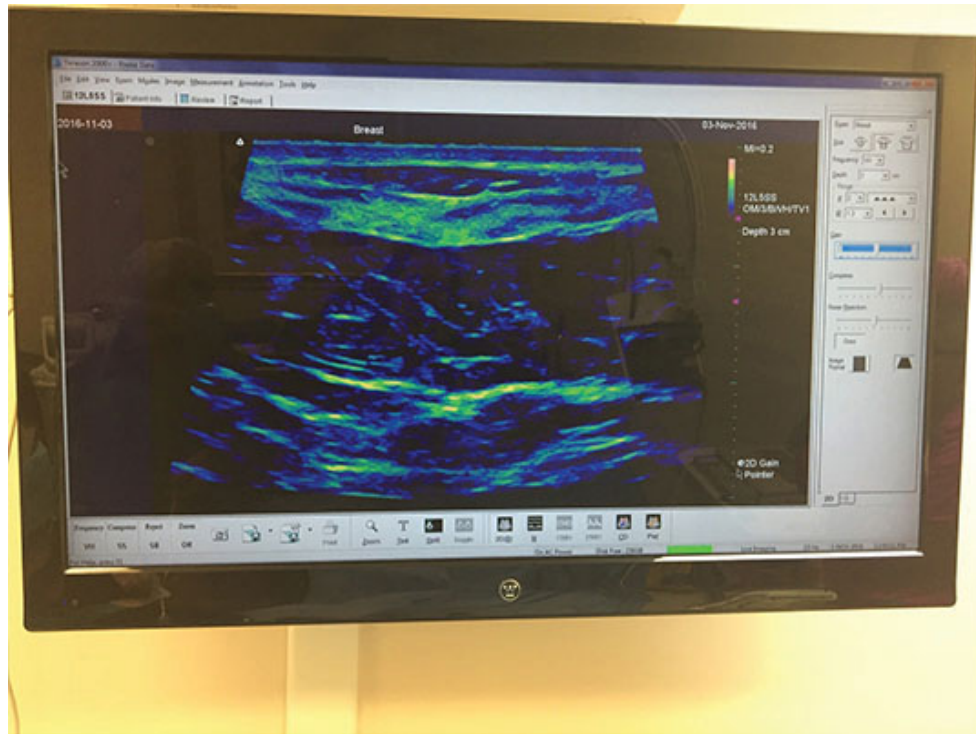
Fat grafting to large body areas: breast—An ultrasound image of the breast is viewed on a large television monitor in the operating room for improved visibility.
